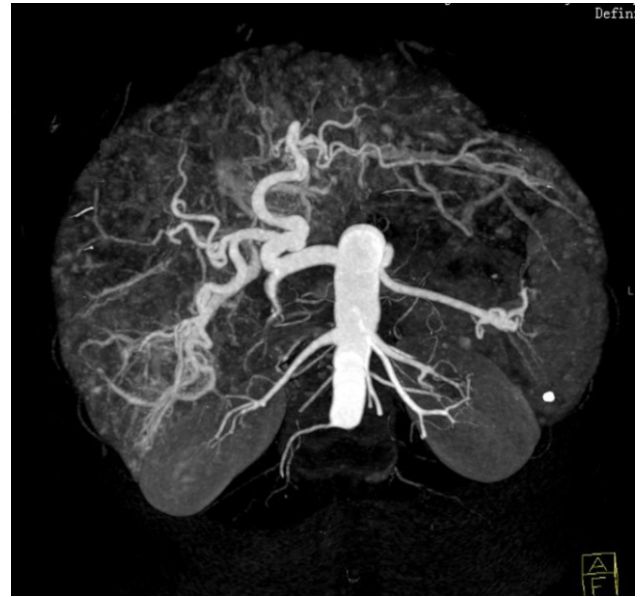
Maximal intensity projection of contrast-enhanced CT scan revealed arterioportal shunts.
